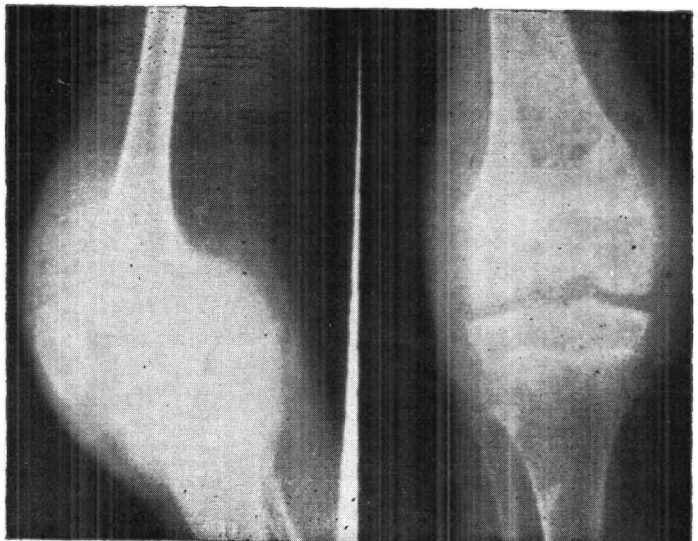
X-ray photographs of knee, A.P. and Lateral views, showing increased joint space without any bony changes.
